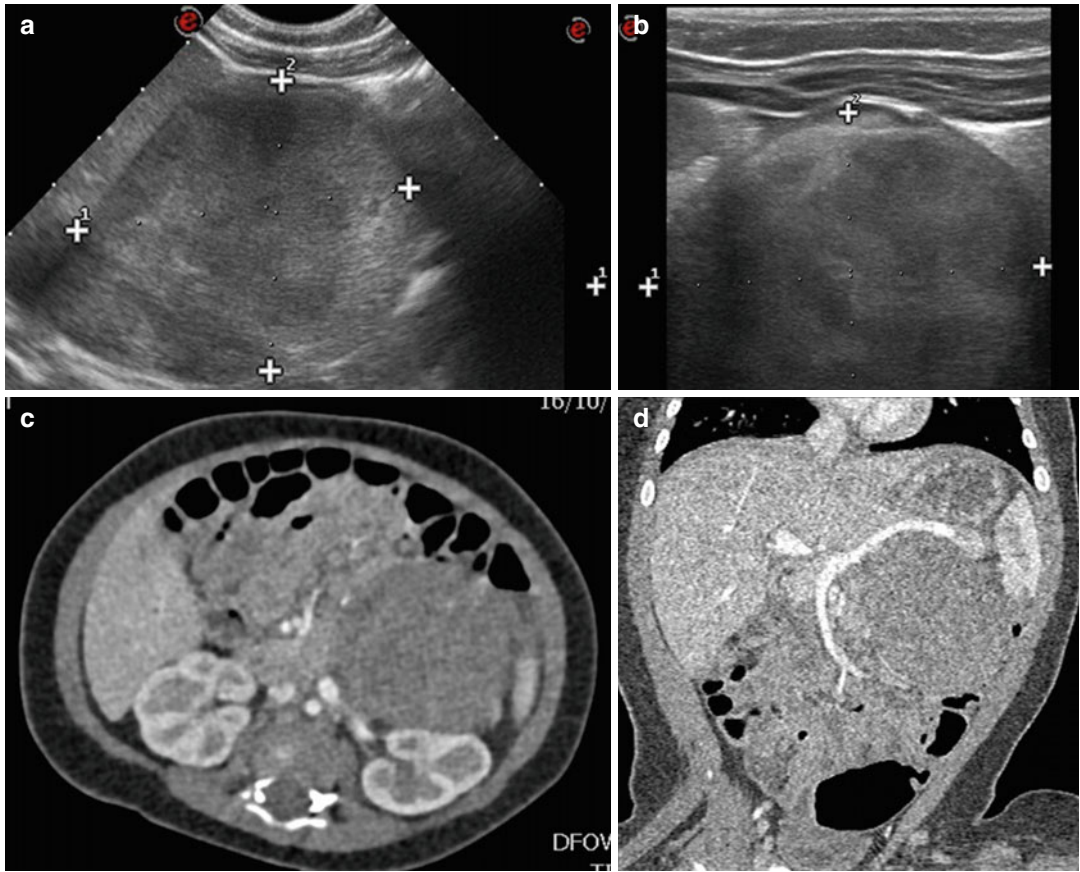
Female, 1 year old. She presents with abdominal distension and nausea. A left adrenal gland neuroblastoma was depicted. US scans (a, b) show a quite homogeneous echogenic adrenal mass. CT (c and d MPR
